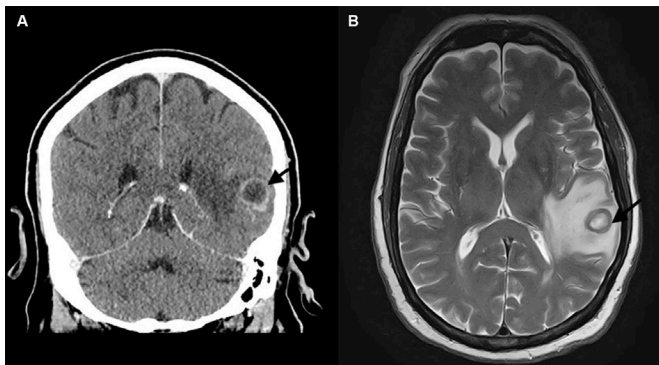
(A) Head CT with contrast, coronal section, showing a left temporal lobe ring-enhancing lesion surrounded by vasogenic oedema (arrow head). (B) Brain MRI, flair sequence, showing left temporal lobe mass surrounded by vasogenic oedema.
